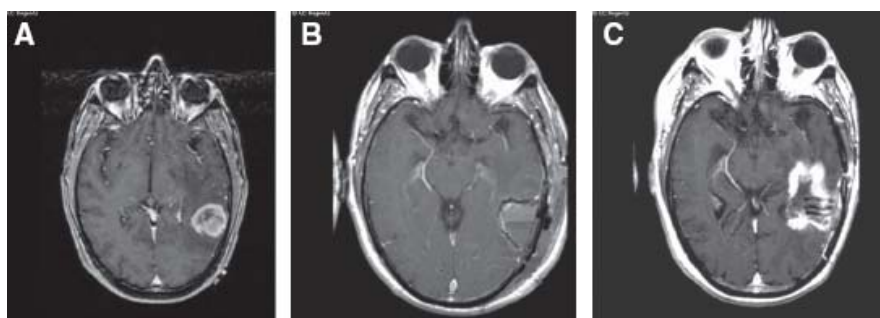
Pseudo progression of a malignant brain tumor post interstitial radiotherapy. A) Axial T1-enhanced MRI shows the tumor mass prior to neurosurgical intervention. B) Immediately post-resection MRI shows changes in brain parenchyma after excision of the tumor mass and 125-I seed placement. C) MRI at 18 months after treatment highlighting pseudo progression, although surgical intervention did not find remnants of neoplasia.
